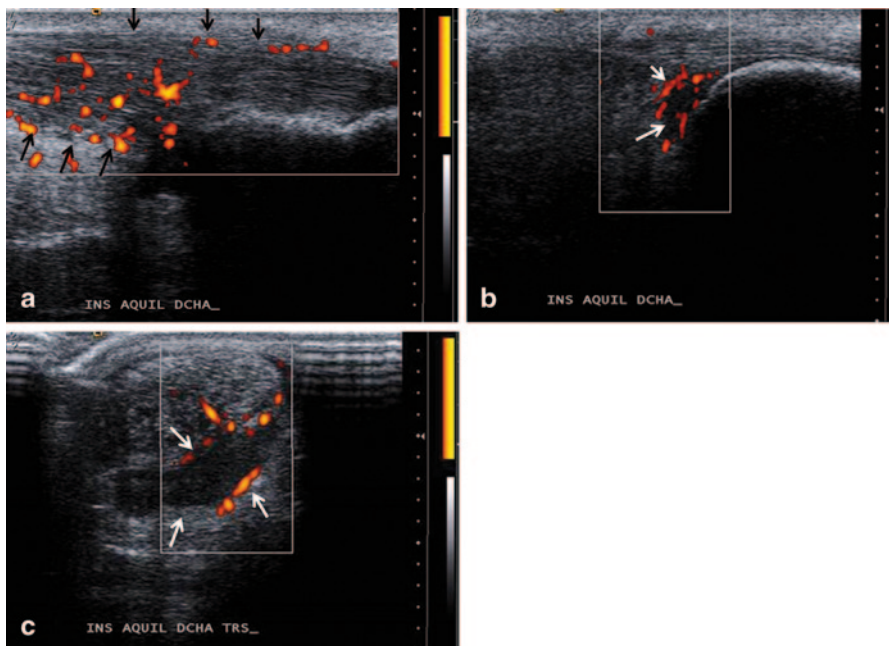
a Achilles tendon enthesitis in a patient diagnosed of psoriatic arthritis. There are thickening and hypoechoogenicity of the Achilles tendon (*black arrows*). In power Doppler ultrasound mode, an increased blood flow can be observed (*long axis*). b, c Retro-calcaneal bursitis in a patient diagnosed of psoriatic arthritis with Achilles tendon enthesitis. US image reveals hypoechoic swelling of the retro-calcaneal bursa deep to the distal Achilles tendon (*white arrows*). The peri-bursal area appears hyper-vascular at color Doppler imaging. b Long axis. c Short axis
